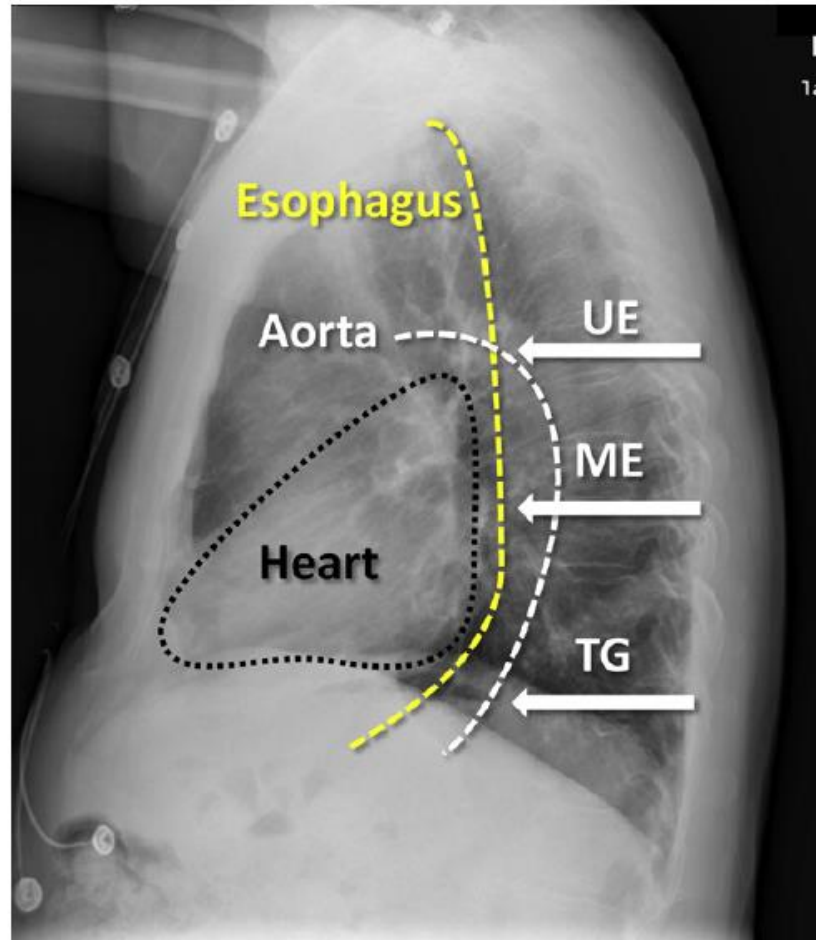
Lateral chest x-ray depicting relative positions of the heart (*black outline*), aorta (*white line*), and esophagus (*yellow line*). Arrows indicate the upper esophageal (UE), ME, and TG positions of the transesophageal echocardiographic probe.
